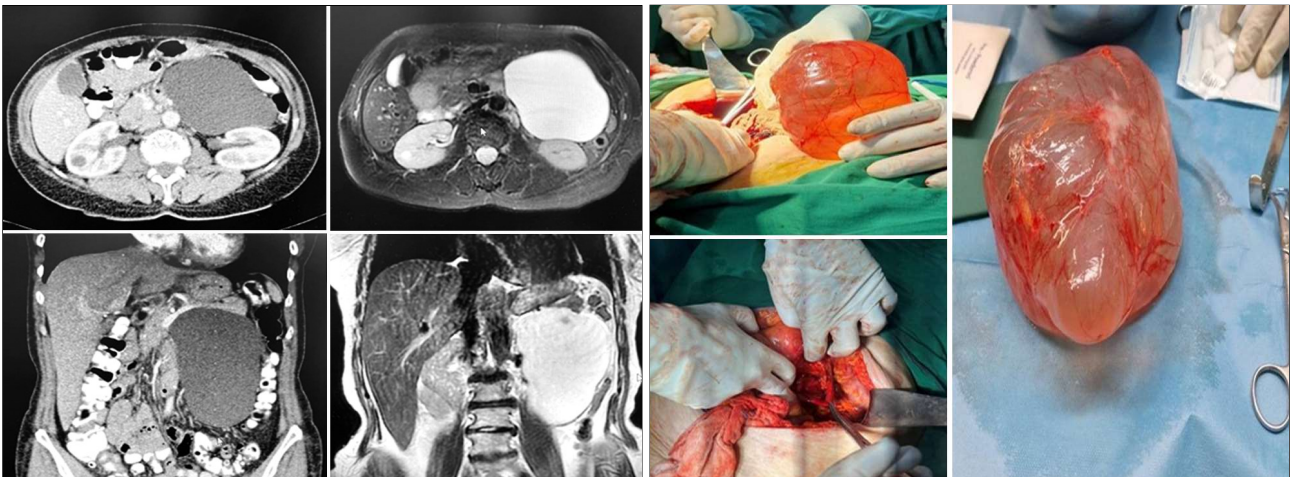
Compilation of the preoperative CT & MR images, demonstrating the presence of fluid-filled cystic lesion, arising from the mesentery of the descending colon and displacing the pancreatic tail in cephalad position
